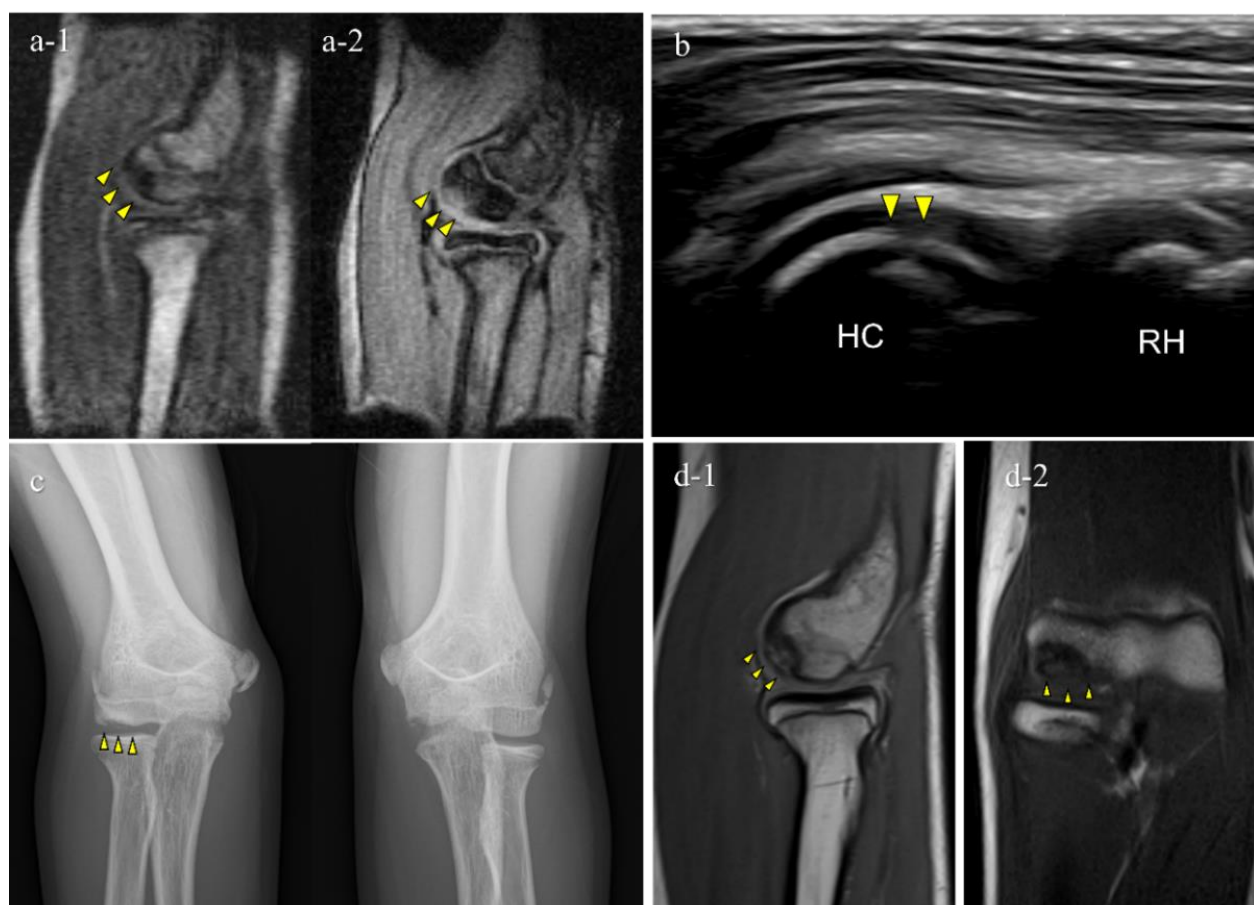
Typical OCD case (Case 3): Mobile MRI (+), US (+). (a) Mobile MR images; a-1, T1WI sagittal image; a-2, T2*WI sagittal image: Mobile MRI depicted the OCD lesion as a low-signal area in a T1WI sagittal image and a high-signal area in a T2* weighted image; (b) US image of the posterior longitudinal view: US showing subchondral bone irregularity; (c) X-p AP view with elbow 45° flexed: X-p 45° showing the lesion with fragmentation, stage II-OCD; (d) 3T MR images: d-1, PDWI sagittal image; d-2, coronal image: localization of the lesion was consistent with that of 3T MRI and mobile MRI.
